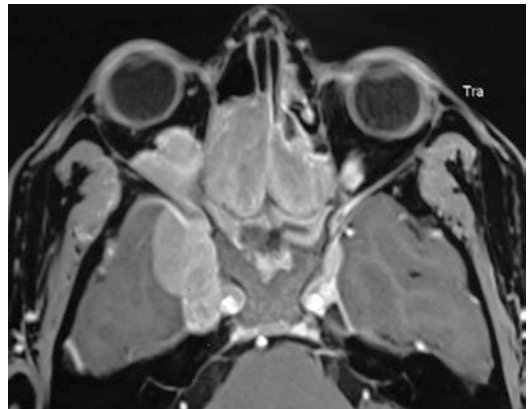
T1W MRI showing a sphenoidal lesion extending into the orbit and involving the skull base
